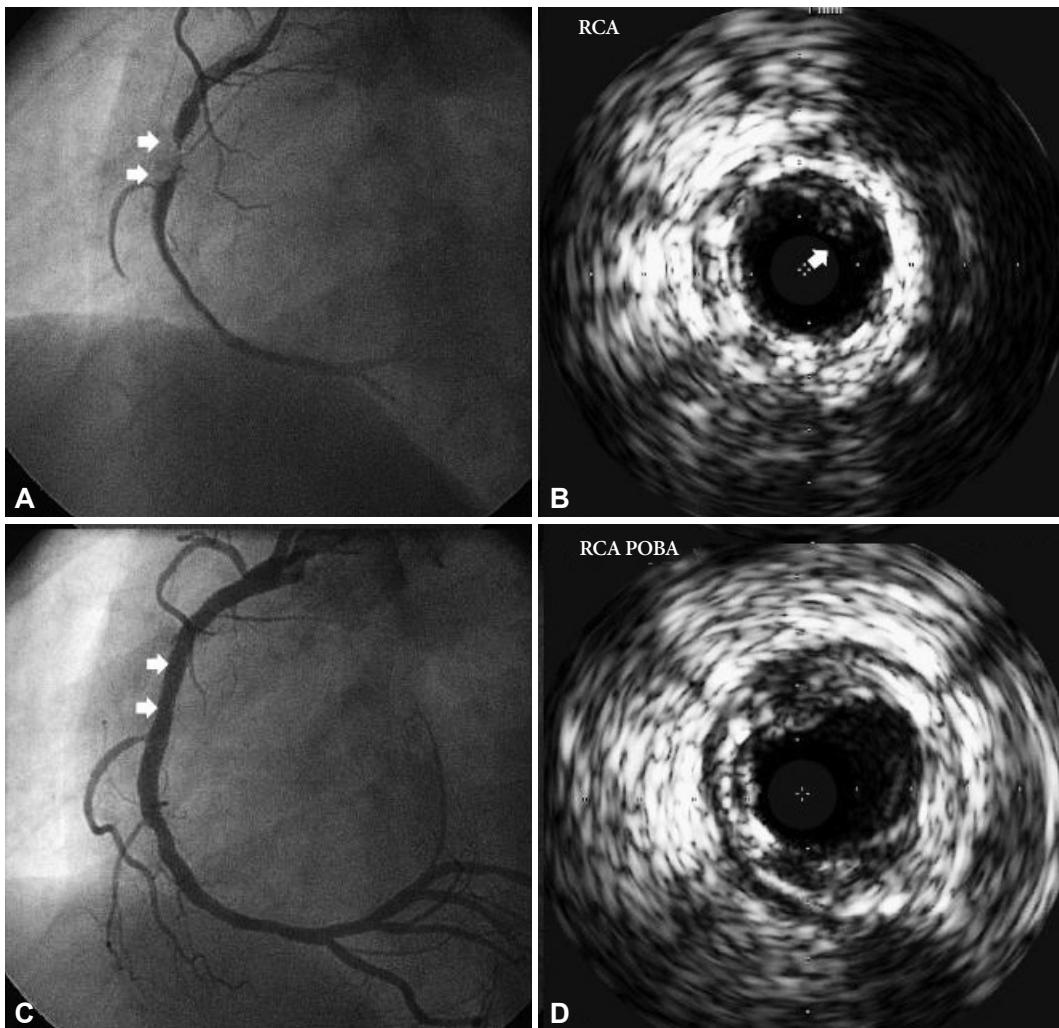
A: right coronary angiogram showed very late stent thrombosis in the right coronary artery (RCA) stent. B: intravascular ultrasound (IVUS) showed neointimal rupture with thrombus within the RCA stent. C: coronary angiography after plain old balloon angioplasty. The final coronary angiogram showed good distal flow in the RCA. D: IVUS showed markedly decreased residual stenosis in the RCA.
